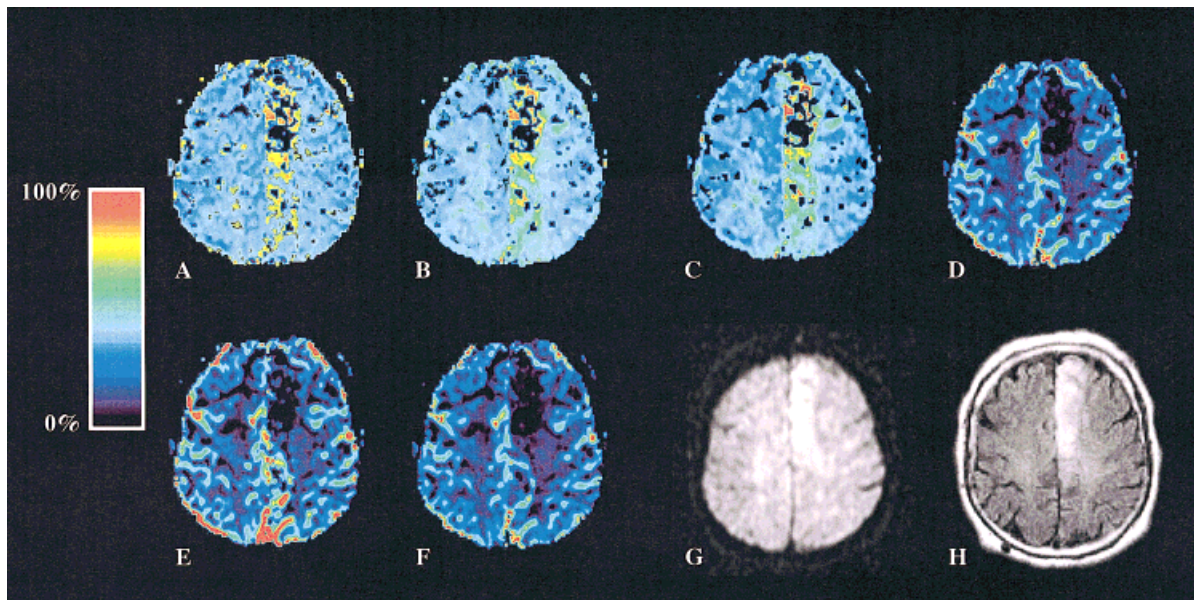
Single slice from same patient who had an infarct in the left anterior cerebral artery territory showing the BAT map (A), TTP map (B), MTT map (C), MAX map (D), CBV map (E), CBF map (F), diffusion trace image (G), and the follow-up FLAIR image (H) more than 24 hours after stroke onset. The calculated maps use the color scale on the left of the figure. The affected area is clearly visible on all the images.
